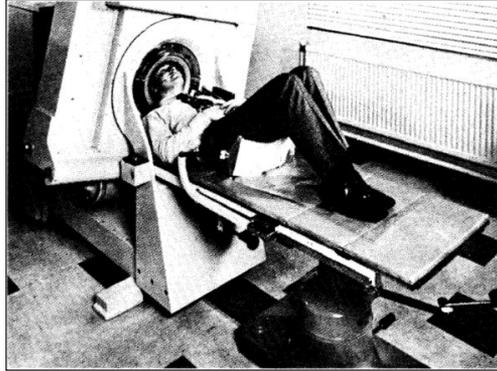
The first clinical computed tomography for the brain installed in London
